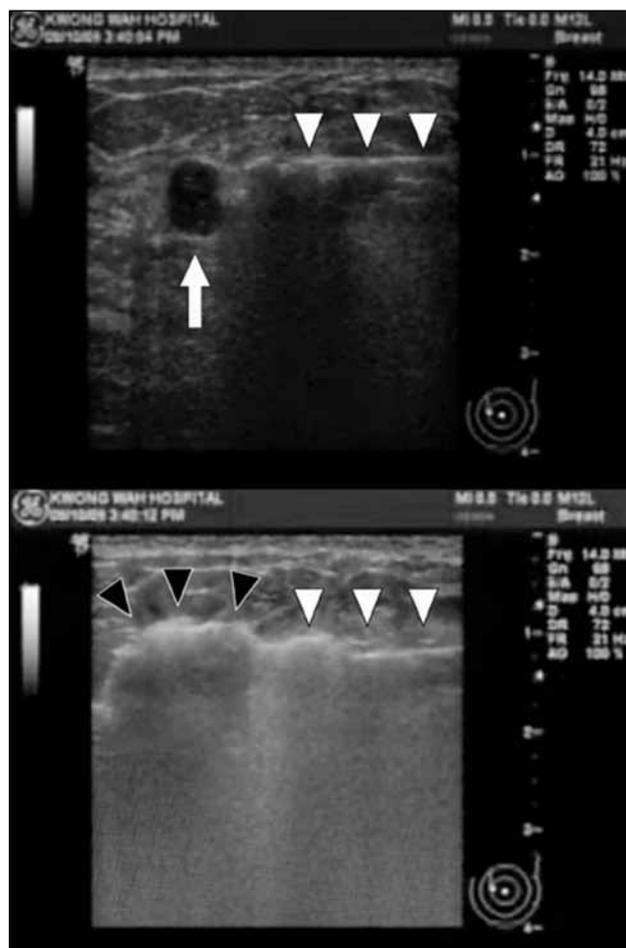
Ultrasound images showing the hypoechoic lesion (arrow) being targeted (top) and after basket deployment (bottom), and the shaft of radiofrequency wand (white arrowheads) and the capture basket after deployment, capturing and obscuring the hypoechoic lesion (black arrowheads).
